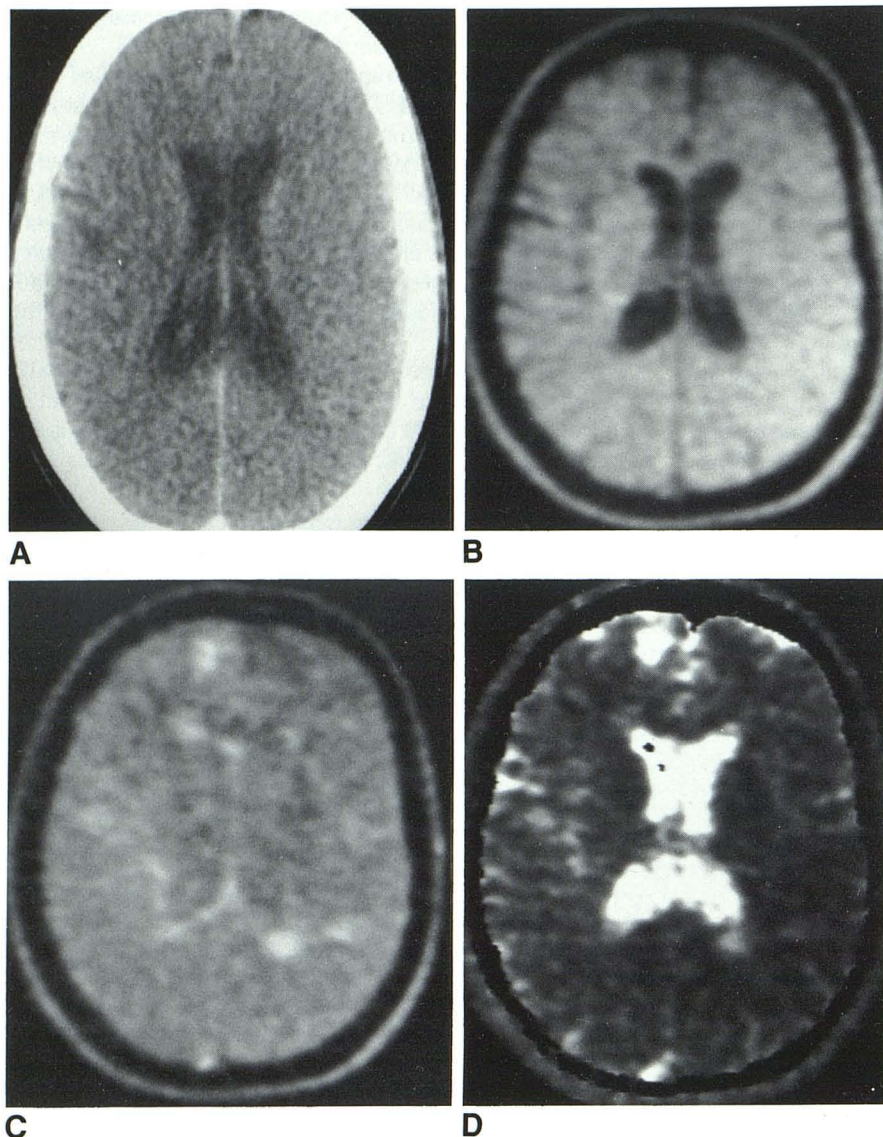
Multiple focal and periventricular plaques (duration of disease: 28 months). A, Delayed enhanced CT image. No significant abnormality. B, Early CPMG image (effective 22.6 msec TE). C, Late CPMG image (sum of SEs 9–16, effective 113 msec TE). D, Calculated T2 image. Diffuse focal and periventricular plaques manifested as prolongation of T2 (T2 of focal plaques, 139–147 msec; T2 of periventricular plaques, 198–230 msec).
